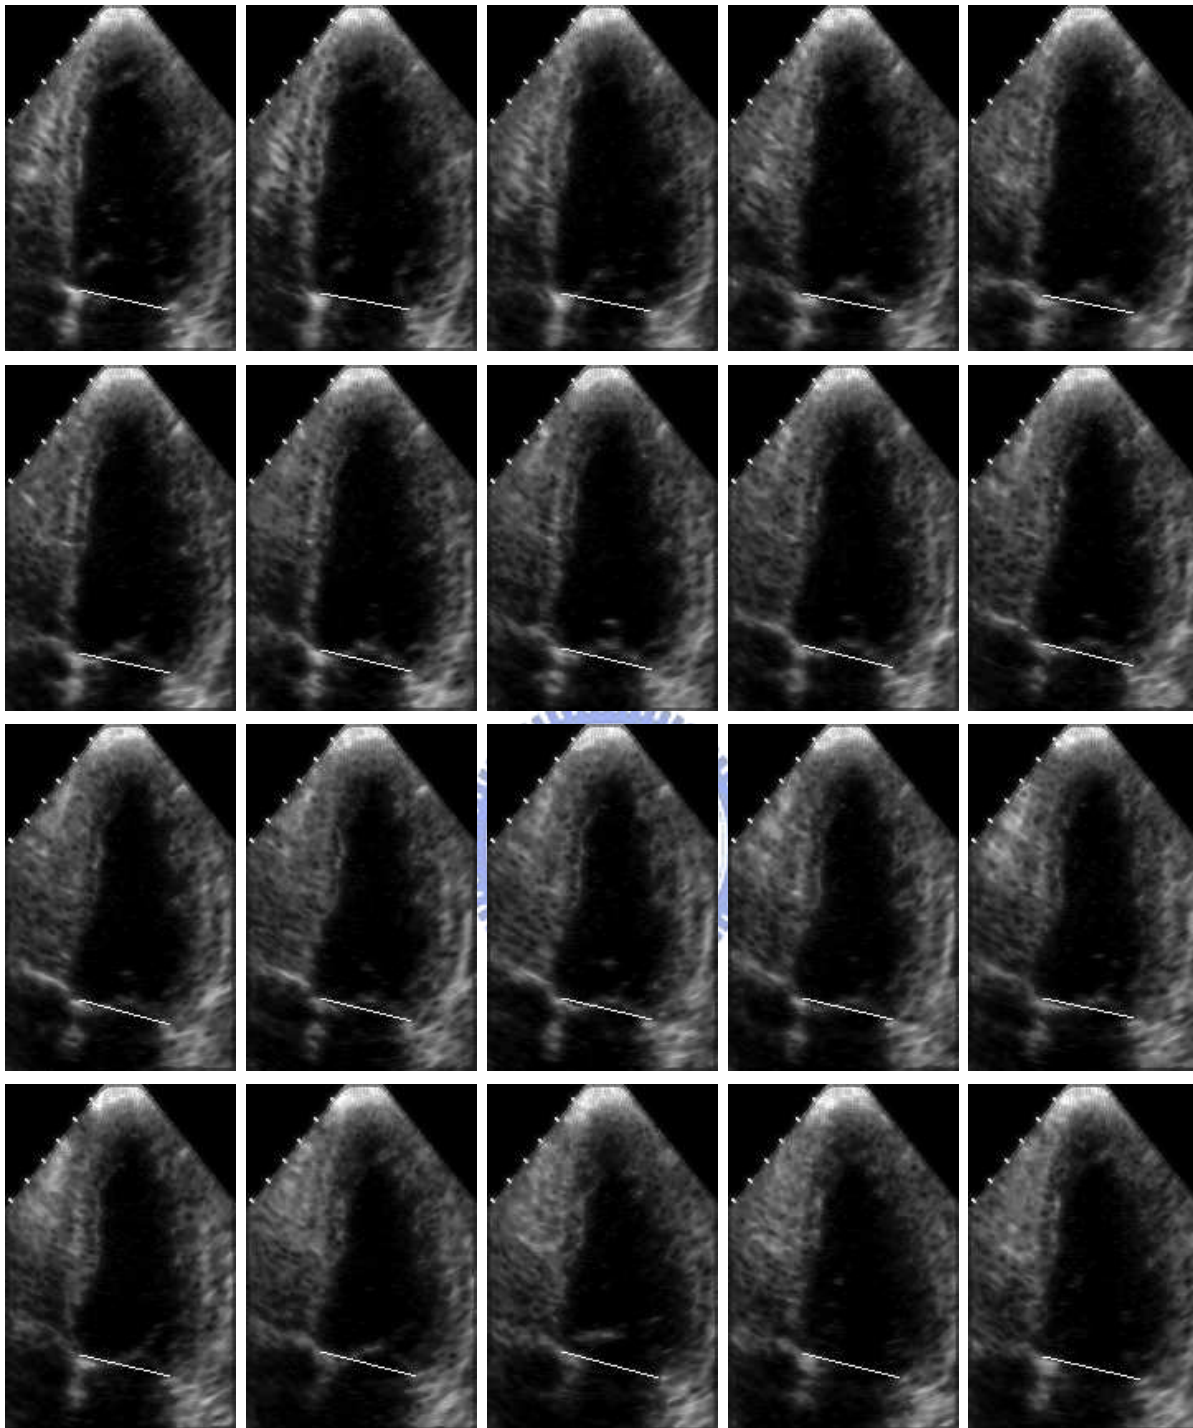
Sequential precordial echocardiographic images in long axis view of an adult healthy volunteer within a cardiac cycle. The white line separating the left ventricle and left atrium is the mitral annular line created by the proposed method.
